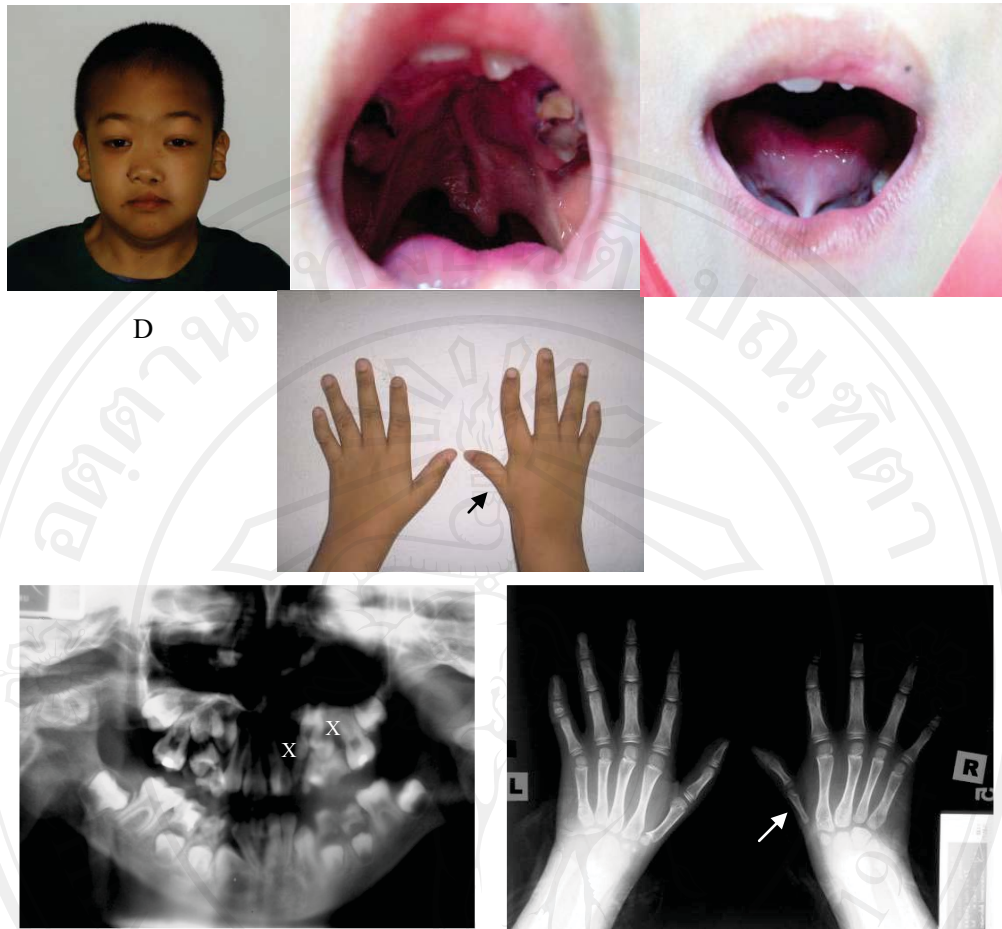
Clinical and radiographic findings of affected patient with *TBX22* mutation. A-D, Clinical features of the patient with cleft lip and palate with ankyloglossia and upper limb abnormalities with the lingual frenum attached from alveolar ridge almost to the tip of the tongue, a thick fibrous frenum, short length of frenum (<1 cm). E, Panoramic radiograph shows teeth 22 and 25 missing. F, Left and right hand radiograph of the proband; the left hand shows tiny trapezoid, trapezium and scaphoid. The right hand shows small size of the first proximal phalange and the first metacarpal, and lack of trapezium and scaphoid.
